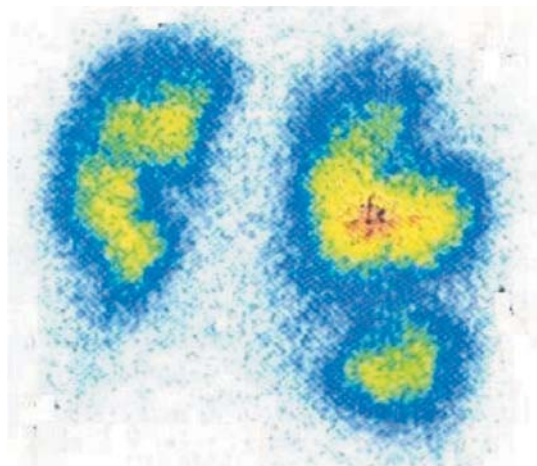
Pulmonary (perfusion) scintigraphy of the *patient C.*, performed on May 15, 2015. The distorted image of both lungs is visualized. The right lung is significantly reduced in size. Non-uniform distribution of the radiopharmaceutical is determined in both lungs, with multiple foci of various sizes with decreased or no pulmonary perfusion, the pathological changes were more severe on the right
